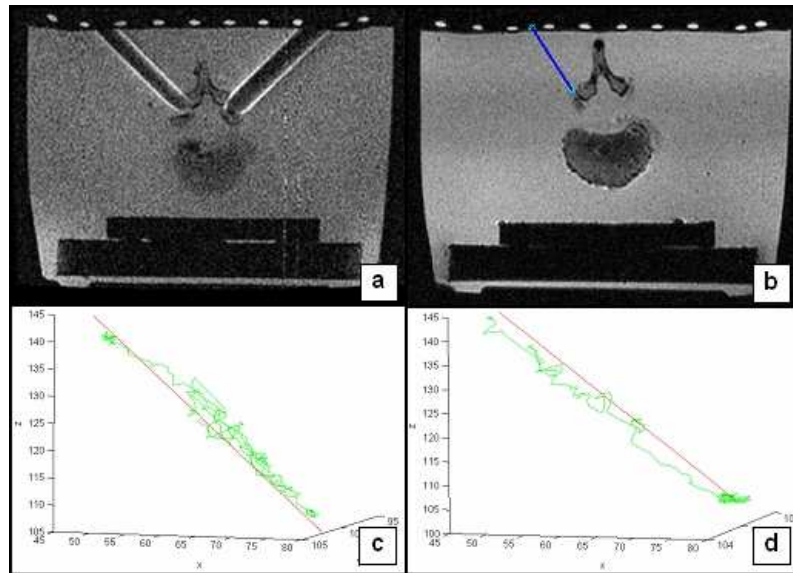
Typical results from an MR image (a) and a tracked path (b). Logged trajectory showing multiple corrections (c) and direct path (d).
